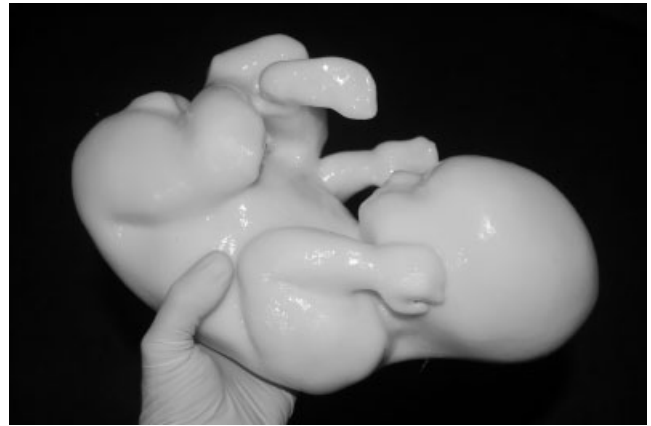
Rapid prototyping model of a fetus created using fused deposition modeling after magnetic resonance imaging at 34 weeks.
